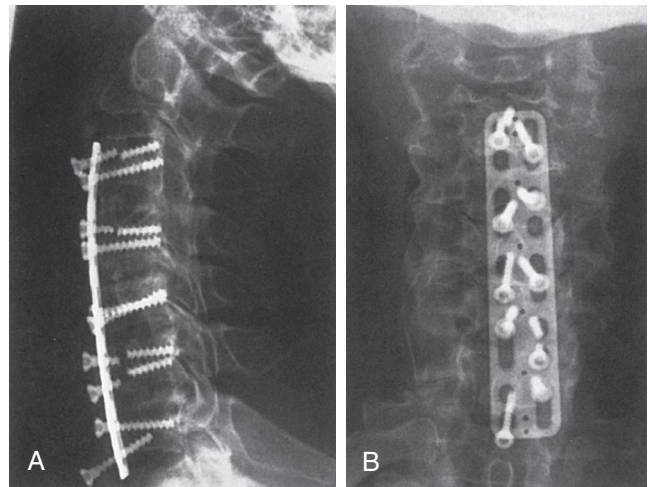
Screws may fracture as a result of excessive stresses placed on them by the subsiding spine, as depicted. A, Anteroposterior radiograph. B, Lateral radiograph. The screws positioned in holes fractured; they could not axially subside. The screws positioned in slots maintained fixation while dynamizing, permitting, and encouraging fusion. (From Benzel EC: Biomechanics of spine stabilization, Rolling Meadows, IL, 2001, American Association of Neurological Surgeons.)
